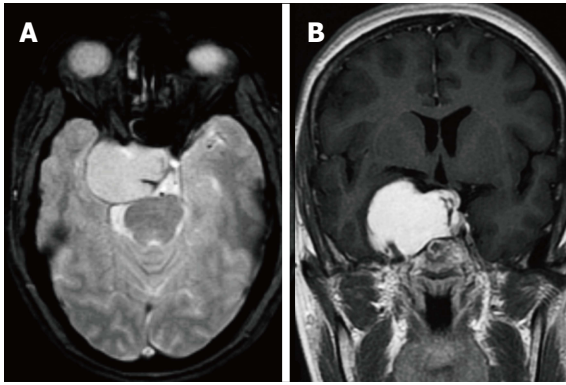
Axial gradient recalled echo and contrast enhanced T1 weighted image axial magnetic resonance images. A: Axial gradient recalled echo sequence does not show any blooming; B: Contrast enhanced coronal T1 weighted image shows intensely enhancing lesion encasing the internal carotid artery.
